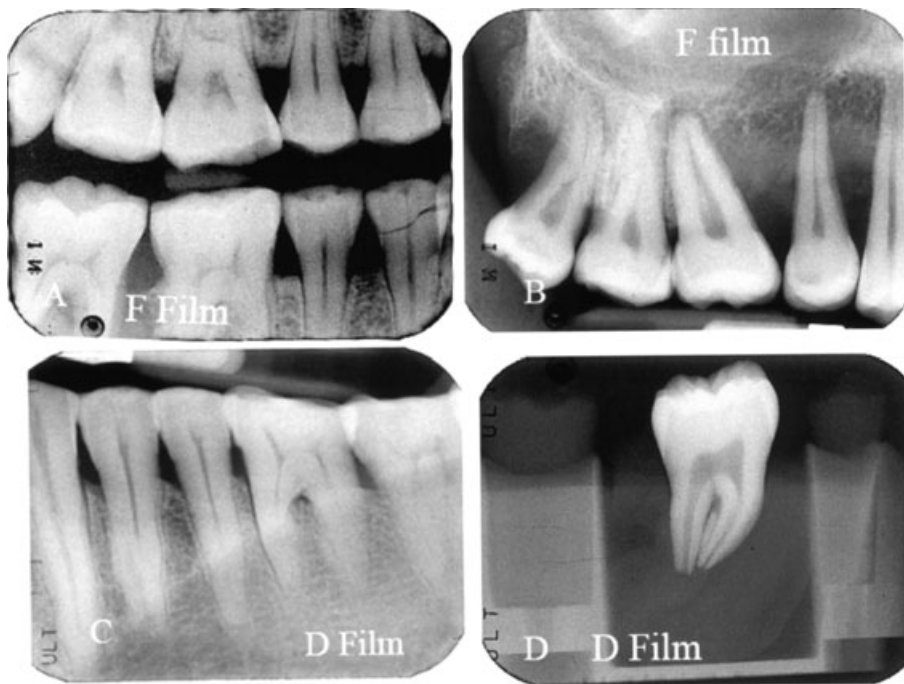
Representative film and digital intraoral study images made with the NOMAD™ X-ray device.
